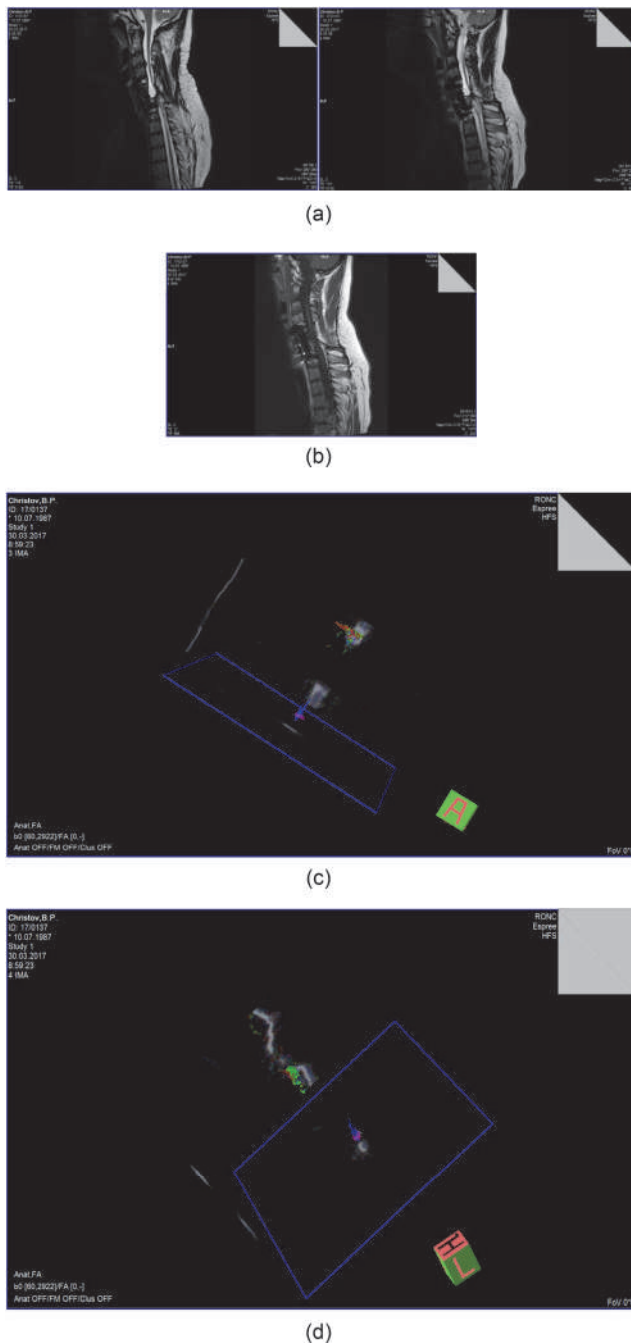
Magnetic resonance imaging of the cervical spine three years post tissue engineering in patient C. MRI Conclusion: SCL, late period. Consequences of the compressive-comminuted fracture of C6 and C7 vertebrae, state post tissue engineering surgery. Corpectomy of C6 and C7. Complete dissection of the medullar substance of the spinal cord at the C6-C7 level with dural sac conductance disorder and MR-signs of subatrophic changes of the medullar substance of the intact segments. (a) T2 mode. (b) T1 mode. The tractography showed that the integrity of the medullar substance at C6-C7 level is disordered for 1.98 cm (while in 2013 the size of dissection was 1.14 cm×1.08 cm) but separate neural fiber bands (c, d) along lateral contours are seen. The CSF canal is obstructed.
